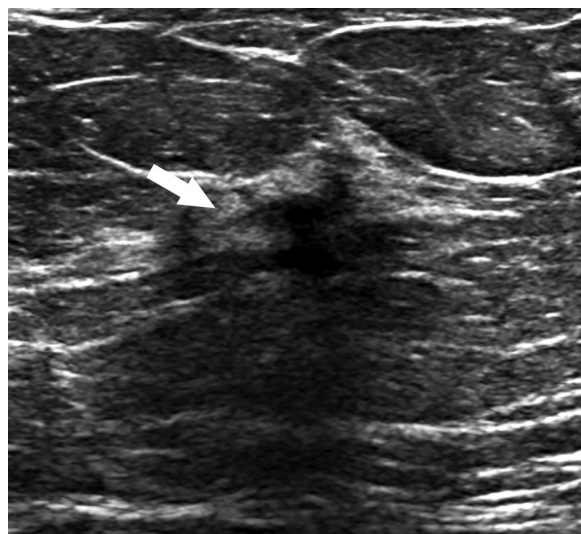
A 57-year-old woman with family history of breast cancer and developing asymmetry on recent mammogram. Cropped grayscale ultrasound image demonstrates an area of architectural distortion (arrow). Follow-up ultrasound-guided core biopsy revealed invasive lobular carcinoma.
